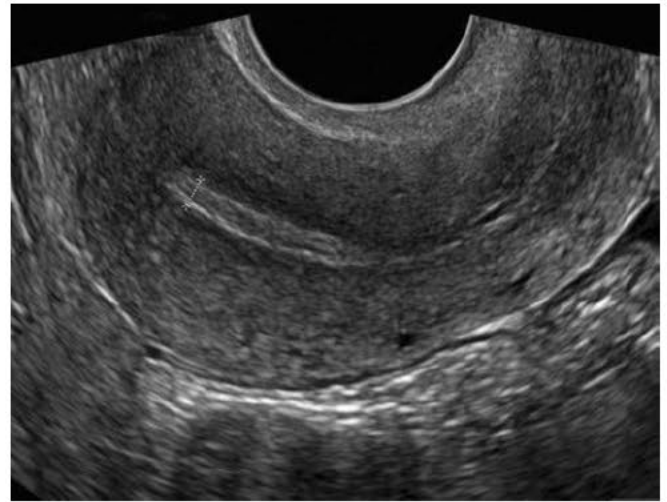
Transvaginal sonogram in the sagittal plane of a menstrual-phase endometrium, which is marked by calipers.
